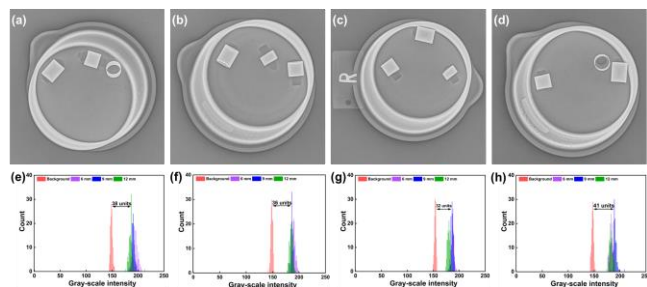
X-ray imaging for increasing lengths of SS316L metal tracer (6, 9 and 12mm) inside tissue mimicking solutions. a) DI water control setup, and agarose gel containing b) 0.2%, c) 0.4%, and d) 0.8% cornstarch content. Image intensity graphs comparing metal tracer intensity to background media for e) DI, agarose gel containing (f) 0.2%, (g) 0.4%, and (h) 0.8% cornstarch filler.
